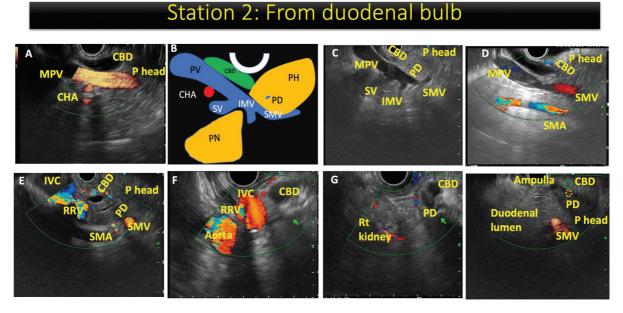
Pancreas examination from the duodenal bulb. (A) The main portal vein (MPV) is the home base in the duodenal bulb. On endoscopic ultrasound (EUS) image, an anechoic common bile duct (CBD) is seen, then main portal vein (MPV) and common hepatic artery (CHA) are visualized in sequence. This is the reverse order of the stomach examination. (B) On slight clockwise rotation, the portal vein confluence (PVC), splenic vein (SV), superior mesenteric vein (SMV), inferior mesenteric vein (IMV), CBD, and pancreas head (PH) along with the pancreatic duct (PD) are visualized. (C) A representative EUS image depicting the same. (D) On slight clockwise rotation, the CBD, PH, SMV, and superior mesenteric artery (SMA) are visualized. (E) On further clockwise rotation, the intrapancreatic CBD, pancreas head (PH), PD, and inferior vena cava (IVC) along the right renal vein (RRV) are seen. (F) On clockwise rotation, the IVC, RRV, aorta, and distal-most part of the CBD seen. (G) On further clockwise rotation, the distal-most part of the CBD and PD along with the right kidney can be seen. (H) Further on fine clockwise rotation, the ampulla can be seen from the duodenal bulb along with the terminal part of the CBD and PD.
